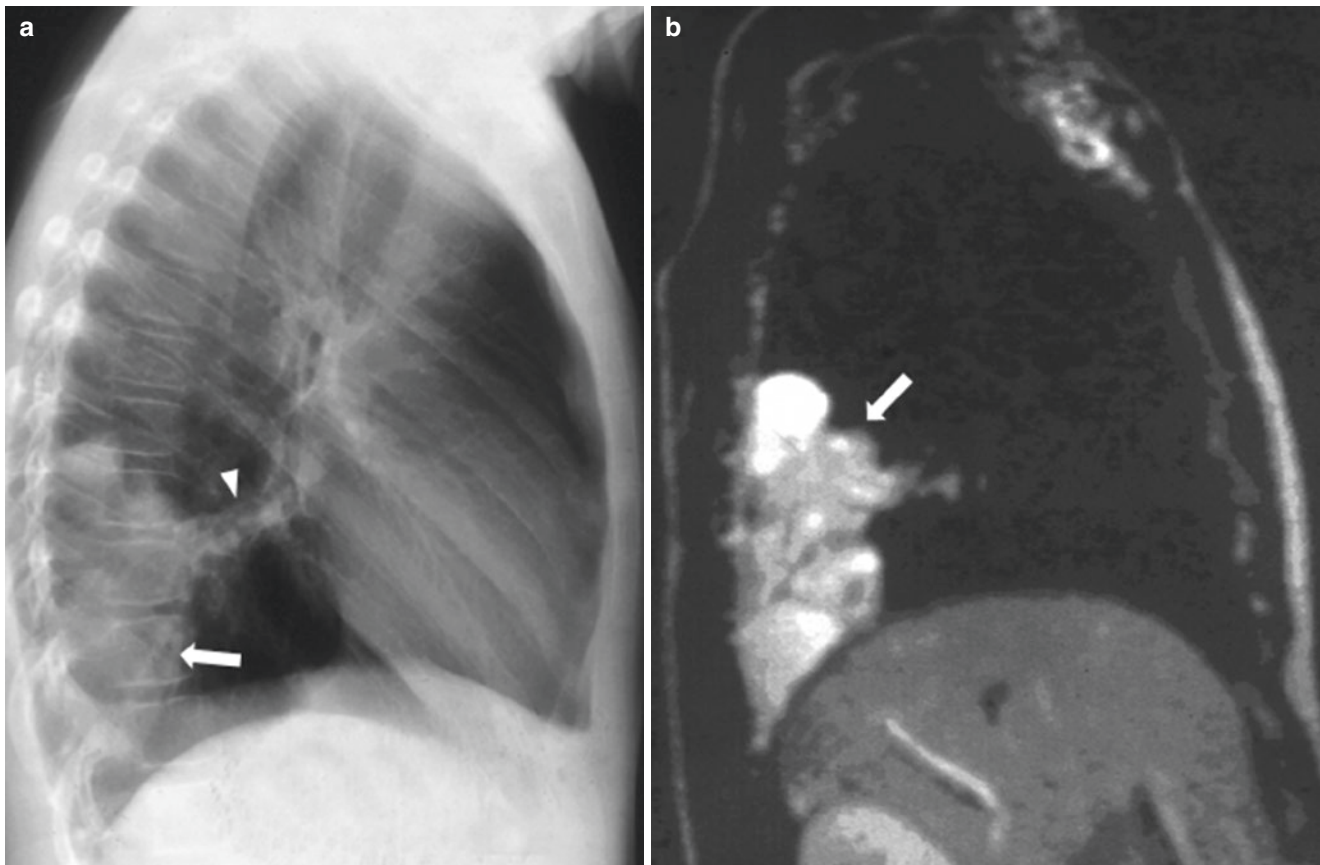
Teenage boy with pulmonary sequestration. (a) Chest radiograph on left lateral view shows a large opacity (arrow) involving the dorsal region of the right lower lobe with a vascular connection (arrowhead) to the right hilum. (b) Sagittal T2-weighted fat-suppressed MR
